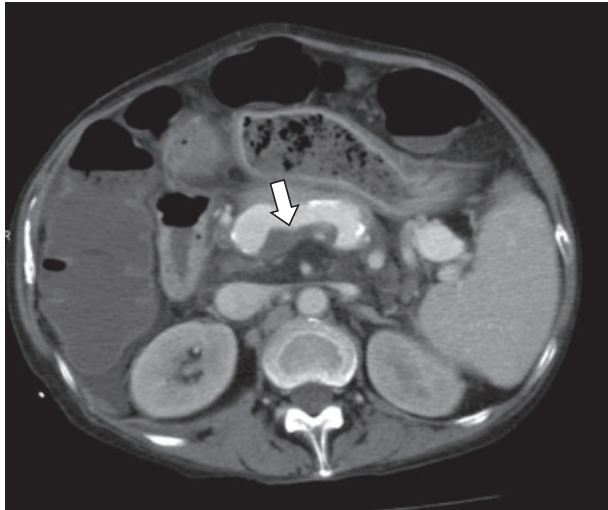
Preoperative computed tomography demonstrated extrahepatic portal vein thrombosis and splenic vein thrombosis (white arrow).
